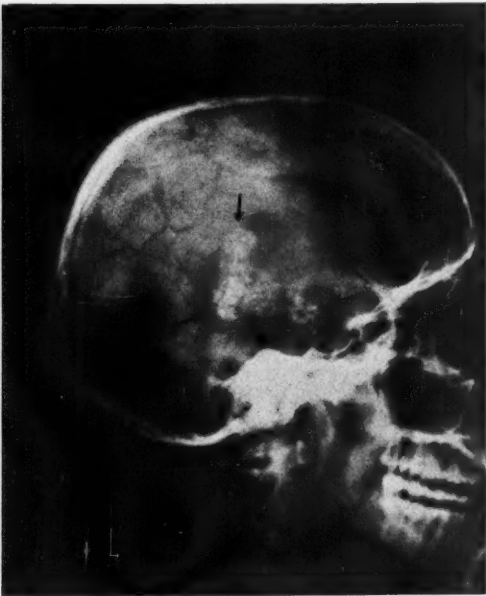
X-ray No. 27,908. Female, age 27. *Complaint:* Headache, failing vision, nausea and vomiting. *P. E. shows* choked discs and left homonymous hemianopsia. *Operation:* Left temporal, with removal of tumor from the temporal horn of the ventricle. *Pathological report:* Meningioma of choroid plexus. *X-ray shows* a sharply outlined, calcified mass in the position of the temporal horn and posterior portion of the lateral horn of the left ventricle, compatible with a calcified tumor of the choroid plexus.
